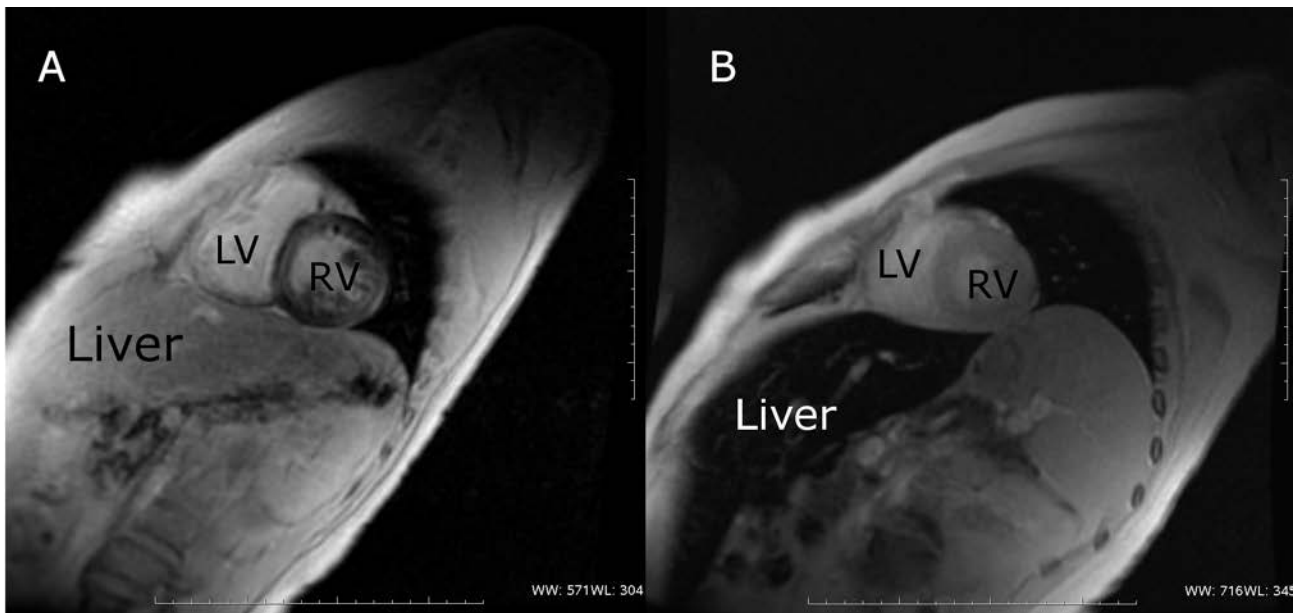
Heart multislice multi-echo MRI T2* obtained with a 1.5 T scanner. Short axis plane shows discordance of liver and heart iron deposition. A: Heart iron deposition, in contrast with minimal liver iron load. B: Severe hepatic iron overload and normal heart iron. (Courtesy of Alessia Pepe, Magnetic Resonance Unit Fondazione G. Monasterio CNR, Tuscany Region, Italy.)
